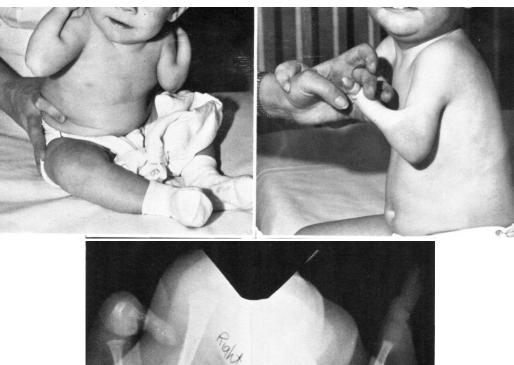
Left, bilateral ulnar hemimelia, with monodigital hands. Right, note the deep web at the cubital fossa (pterygium). Center, X-rays reveal the radiohumeral relationship. There is no true elbow joint.
